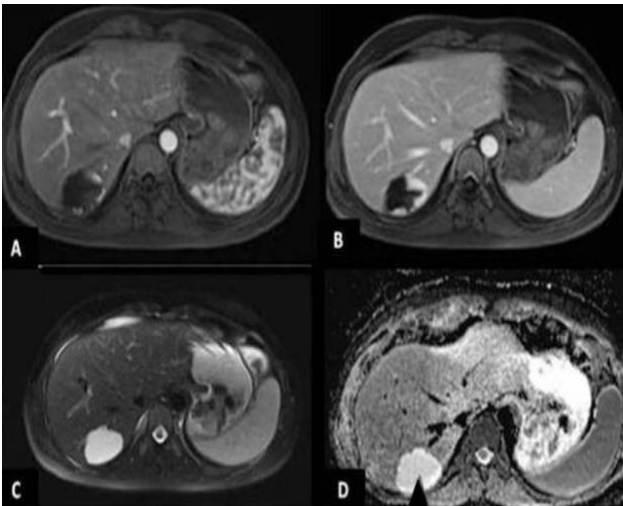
The male patient in 38-year-old. In the dynamic liver MRI of the patient, it is seen that the hemangioma shows peripheral nodular enhancement and progresses towards the center (a, b). The giant hemangioma observed in segment 6 in the fat-suppressed T2W image (c) is significantly hyperintense compared to the liver parenchyma. In ADC mapping (d), the mean ADC value of the lesion (arrow) was $1.85 \times 10^{-3} \text{ mm}^2/\text{s}$, while the average ADC values obtained from the healthy liver were measured as $1.07 \times 10^{-3} \text{ mm}^2/\text{s}$.
